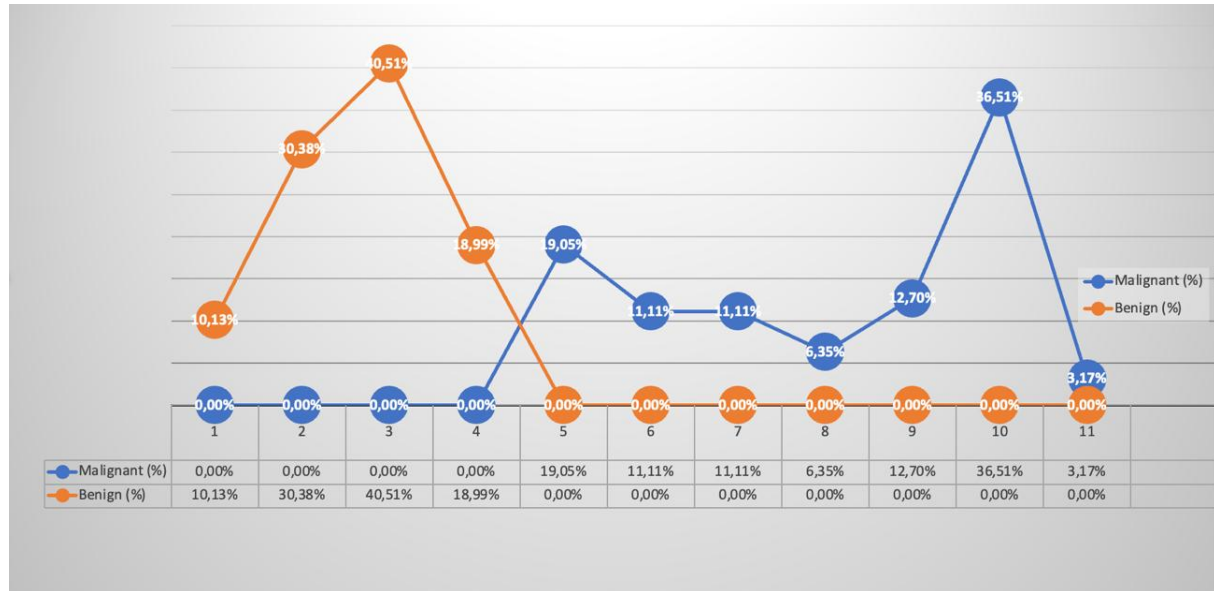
Distribution of Modified X-Ray Scoring System
